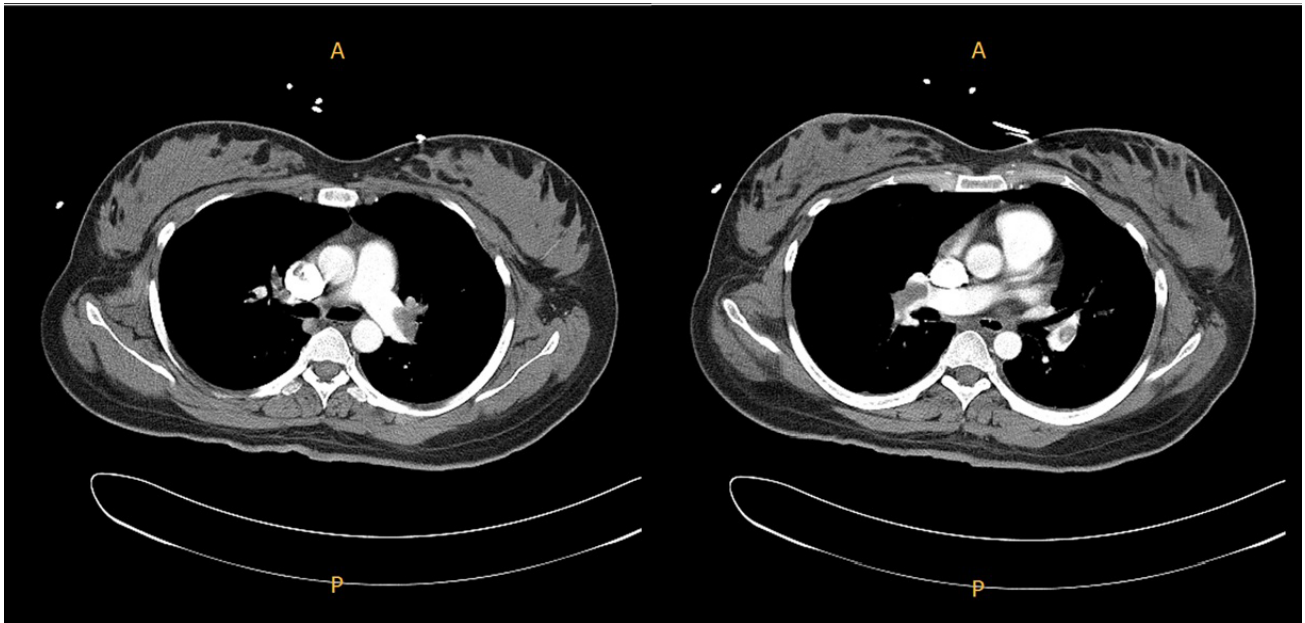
Contrast-enhanced chest CT shows pulmonary thromboembolism at both main pulmonary arteries, both descending pulmonary arteries, truncus anterior, segmental branch of left upper, descending pulmonary artery.
